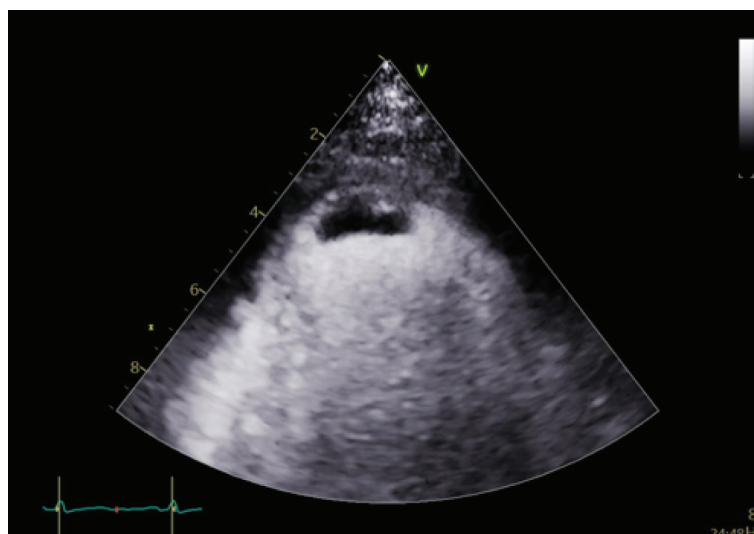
Contrast-enhanced echocardiogram demonstrates a left ventricular apical thrombus.
